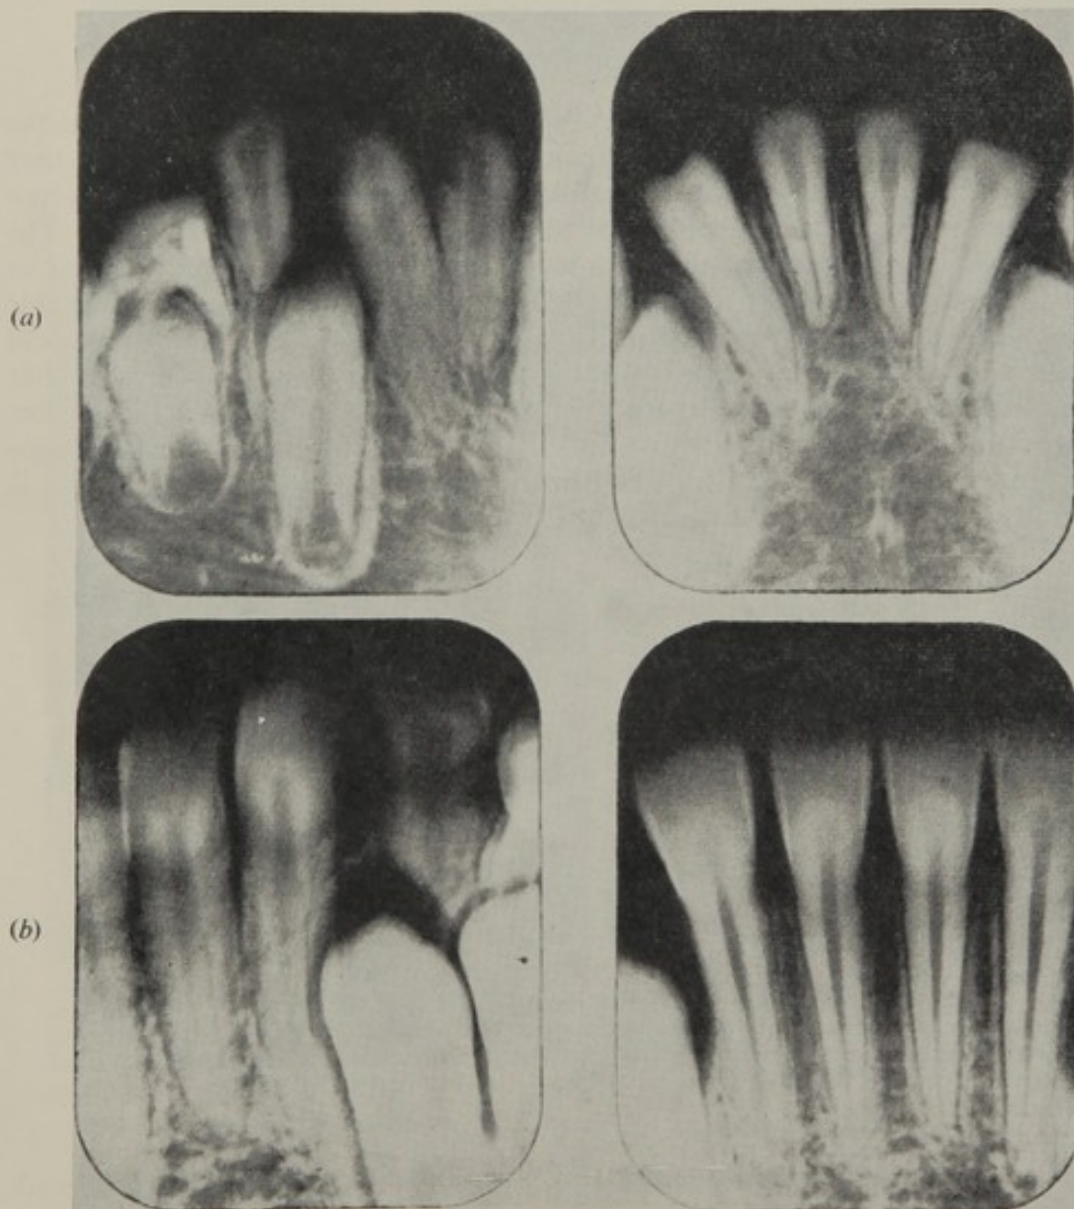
Hereditary hypoplasia of enamel. (a) Radiographs of lower anterior teeth in an affected child aged $7\frac{1}{2}$ years. (b) Radiographs from a normal child for comparison. The almost complete absence of enamel can be detected on erupted and unerupted teeth, and the former already show marked attrition.
